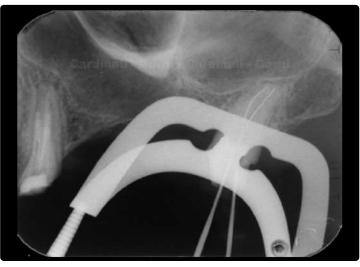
Intra-operative radiograph of case in figure 4.
